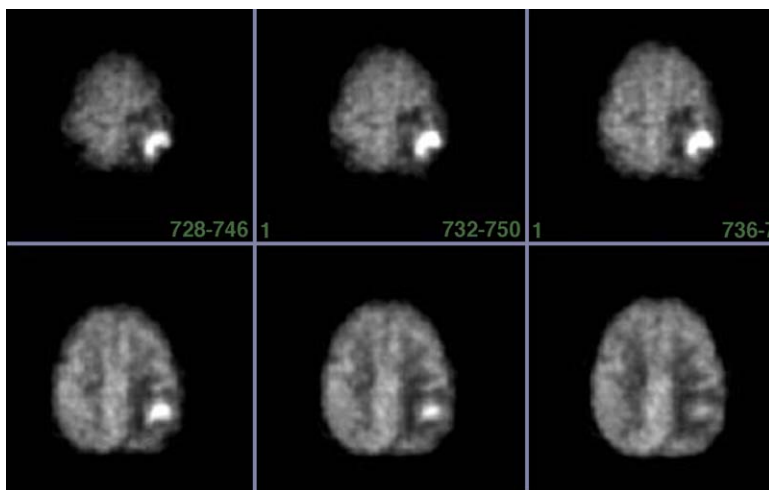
FDG-PET scan of a patient with astrocytoma in the right parietal lobe status post-surgical resection and radiation therapy now with clinical concern for recurrence. The scan demonstrates a large area of intensely increased metabolism in the right parietal lobe consistent with recurrent tumor.
